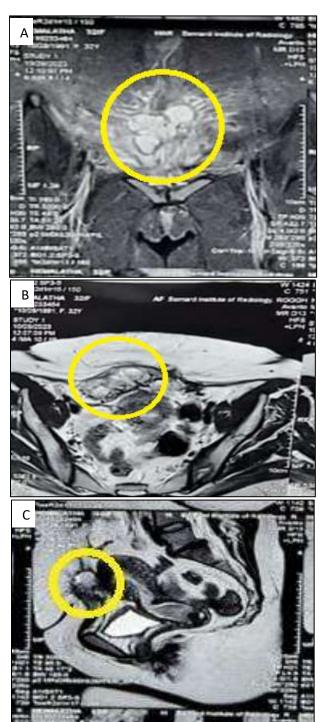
(A-C): MRI showing relatively well defined multiloculated cystic lesion (5.5×2.3 cm) with blood fluid level in rectus sheath extending posteriorly into myometrium which shows peripheral enhancement on contrast administration.
